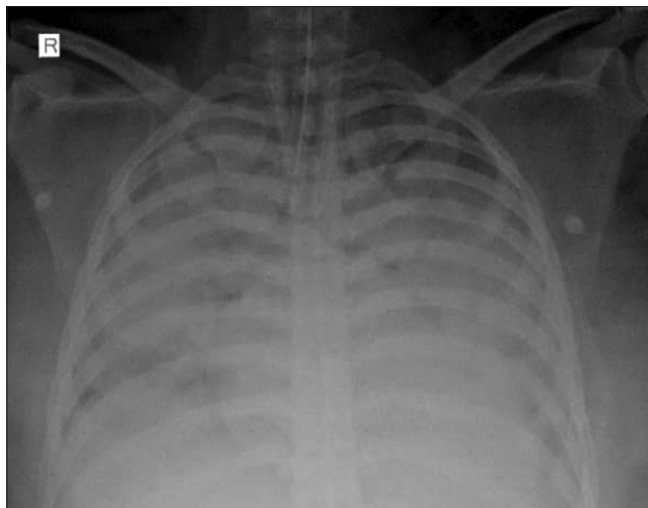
CXR on admission. CXR: Chest X-ray
